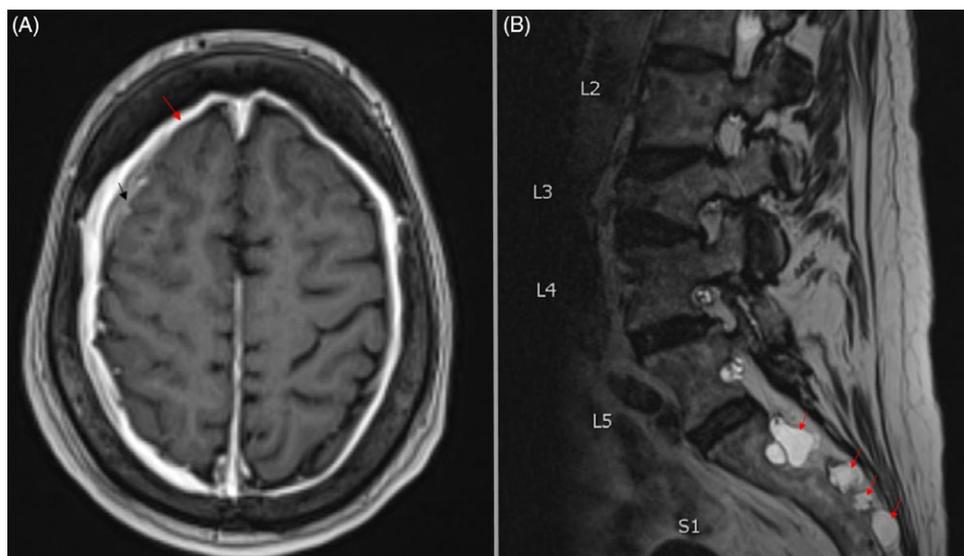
(A) Axial T1 brain MRI with contrast shows pachymeningeal enhancement (red arrows) and subacute SDHs (black arrows), measuring up to 10 mm on the right and 4 mm on the left. (B) T2 sagittal lumbar and sacral MRI shows multiple meningeal cysts (arrows).
